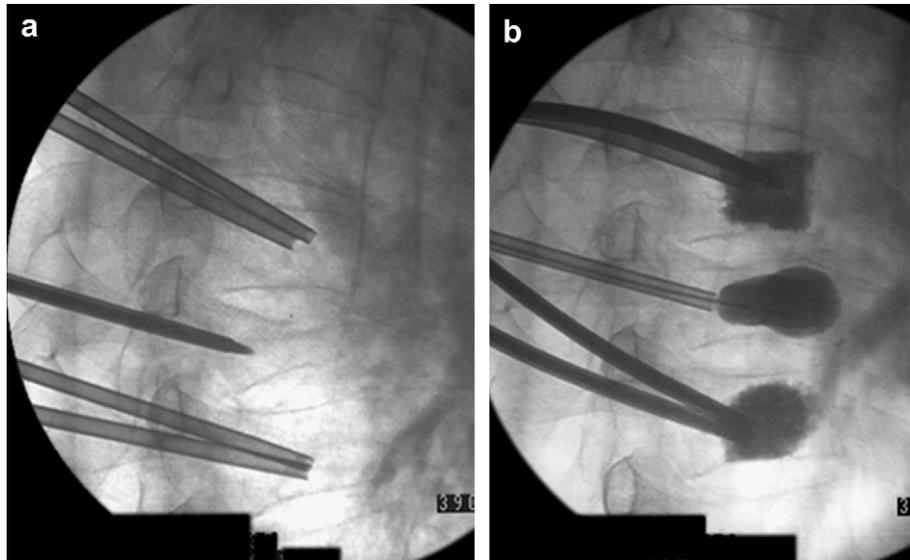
(a) Three-level vertebroplasty and kyphoplasty. Lateral radiograph showing the trocars inserted into the three vertebrae that are to be treated. (b) The top and bottom vertebrae have undergone vertebroplasty, with the injected PMMA radio-opaque cement visible. The middle vertebral body is undergoing a kyphoplasty, with the balloon tamp being inflated.
